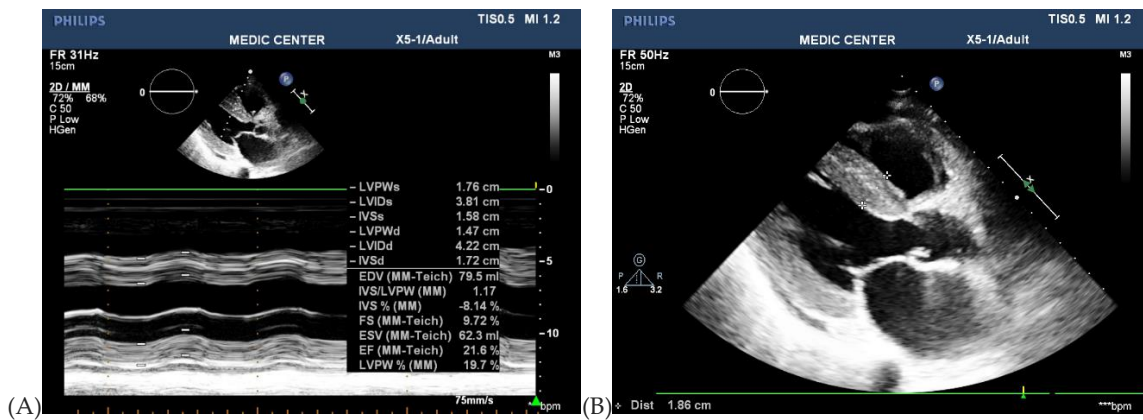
A: Parasternal LAX view demonstrated the thickening of LV walls (IVSd=17mm, PWd=15mm) with marked reduce of LV systolic function (EF= 21.6%). B: LAX view especially revealed the myocardial infiltration which was seen as the typical ground glass appearance.
